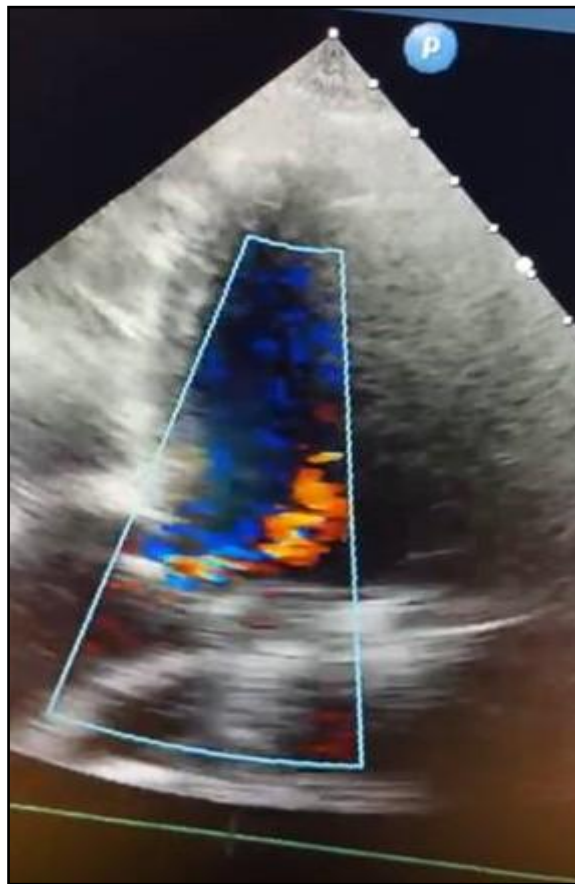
Preoperative Transthoracic Echocardiography
